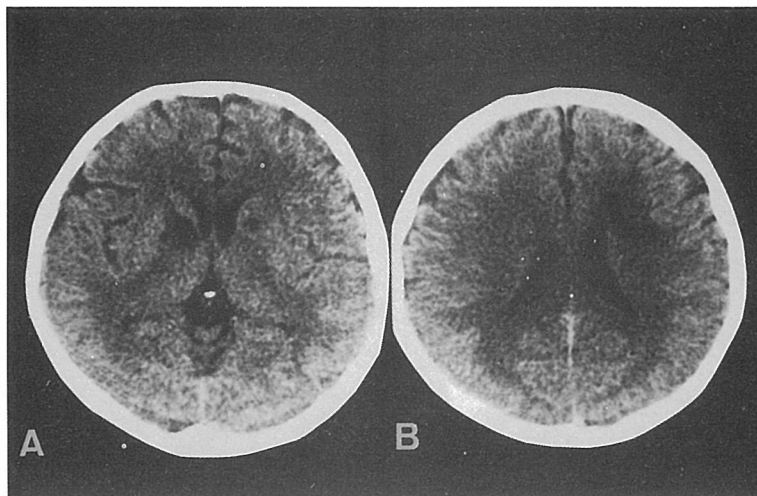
Computerized tomography (CT) scans in case 1. Plain CT (A and B) shows small multiple infarcts in bilateral internal capsules and frontal white matter in the right paraventricle.
